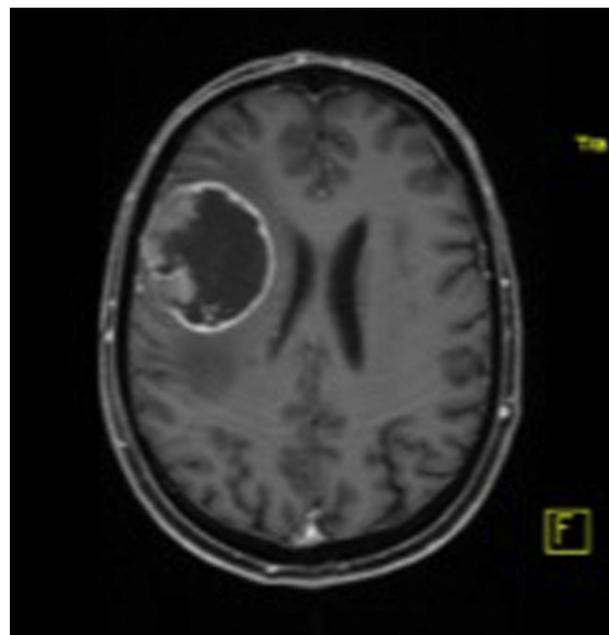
Preoperative gadolinium-enhanced T1 magnetic resonance imaging showing circular contrast enhancement.
